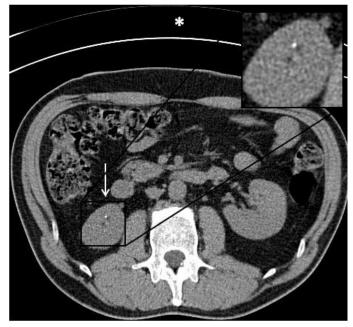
45 year old man with left flank pain revealing a tiny non-obstructing calculus in the right interpolar region. Axial unenhanced CT of the abdomen and pelvis (window level 35 HU, window width 350 HU) with the patient in the prone position (* indicates the CT table top) demonstrates a small calcific density (white arrow) within the interpolar region of the right kidney with no evidence of proximal obstruction. The area of interest is magnified in the upper right corner (Protocol: 120 kV, 95 mAs, 3 mm slice thickness).
